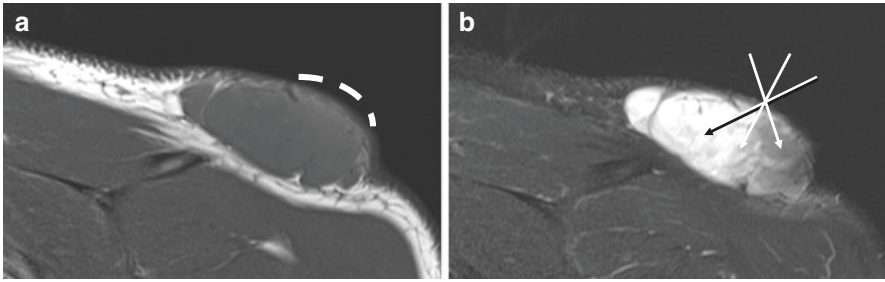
(a) T1 MRI demonstrating large subcutaneous sarcoma. In order to minimise dissection, open biopsy can only sample tissue directly beneath the skin incision (dashed line). (b) T2 fat-saturated MRI demonstrating heterogeneous signal within subcutaneous sarcoma. Through a single entry point on the surface, multiple core needle biopsies may be obtained to sample different regions of the sarcoma
